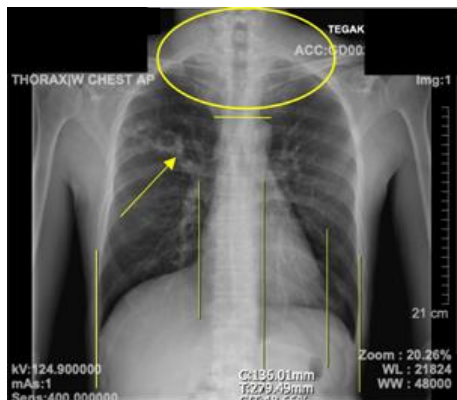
Patient's chest X-ray. Cavities with surrounding infiltrates in the upper field of the right lung, DDx: active pulmonary tuberculosis. Widening of the superior mediastinum. Thickening of soft tissue with multiple air lucencies within the visualized bilateral neck region, suggestive of an infectious process.
